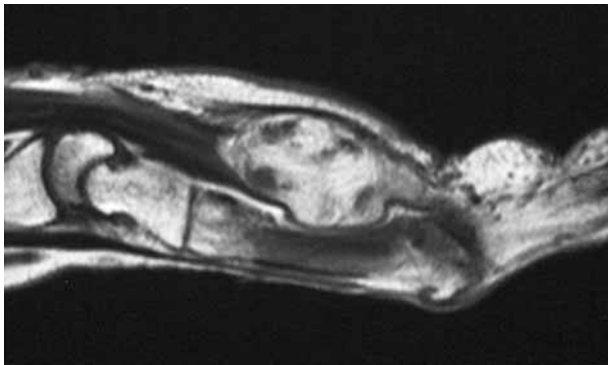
MRI scan showing a soft tissue tumour in the hand palm. No infiltrative tumour growth is evident.
